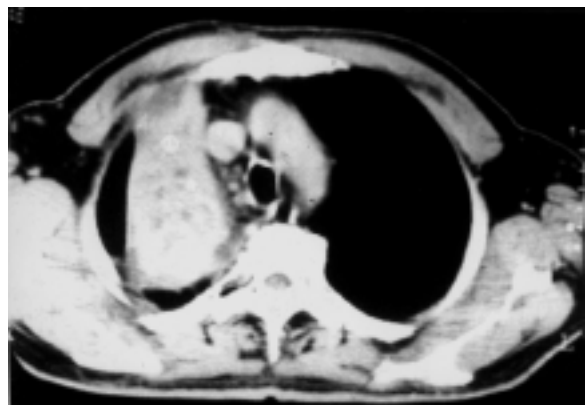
CT scan chest; huge central bronchogenic carcinoma.
